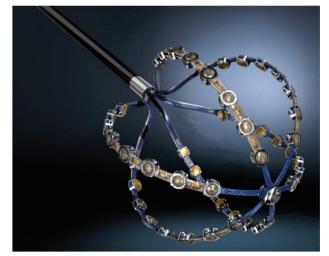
The "Katheter" by "Acutus Medical" is part of a system designed to construct 3-D images and maps of the heart electrical activation using ultrasound micro-transmitters and sensors.
